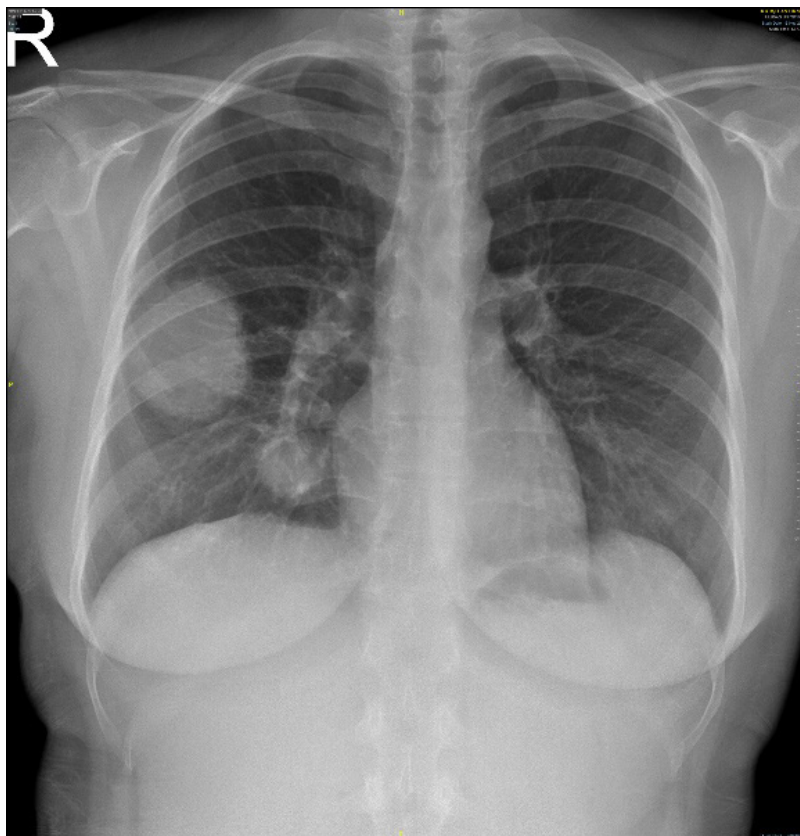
Chest radiograph
